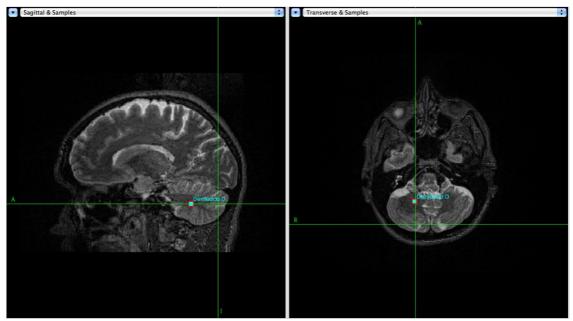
Neuronavigation of the dentate nucleus in sagittal and transverse samples using T2 volumetric magnetic resonance imaging.
